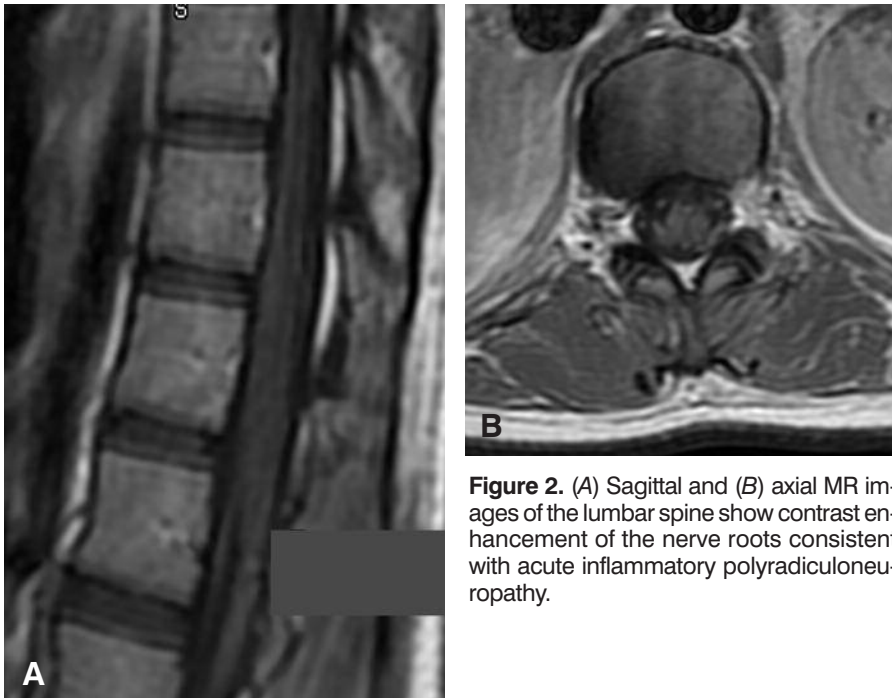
(A) Sagittal and (B) axial MR images of the lumbar spine show contrast enhancement of the nerve roots consistent with acute inflammatory polyradiculoneuropathy.
